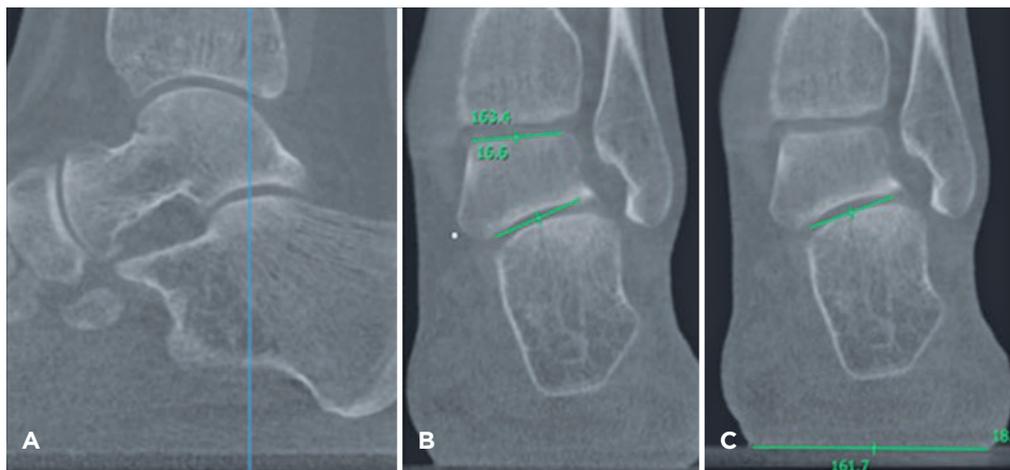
Angular measurements and subluxation parameters used in the three-dimensional assessment of the hindfoot using weight-bearing computed tomography (A). (B) Inftal-suptal. (C) Inftal-hor.
